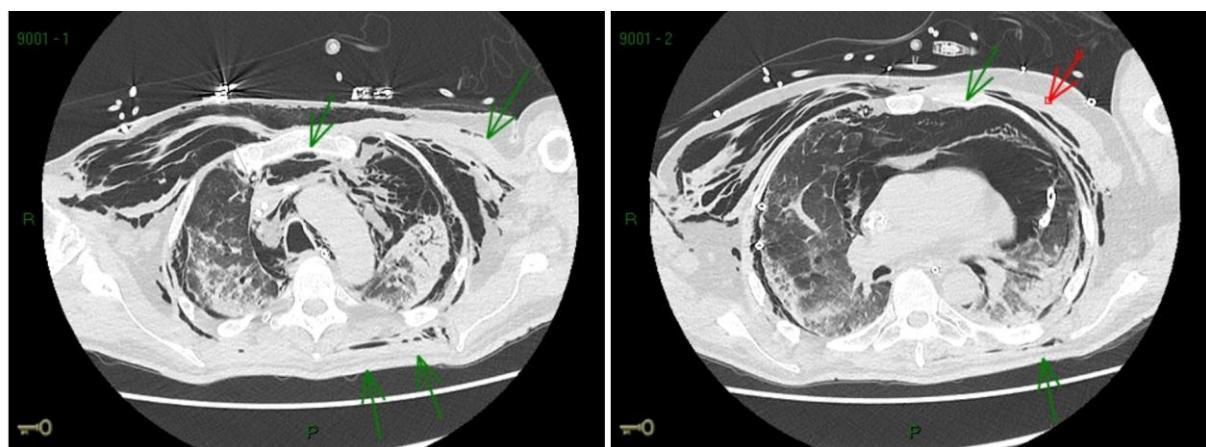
Chest CT on D+44 showing extensive mediastinal emphysema (causing posterior displacement of the heart) and subcutaneous emphysema along the entire thoracic wall.
